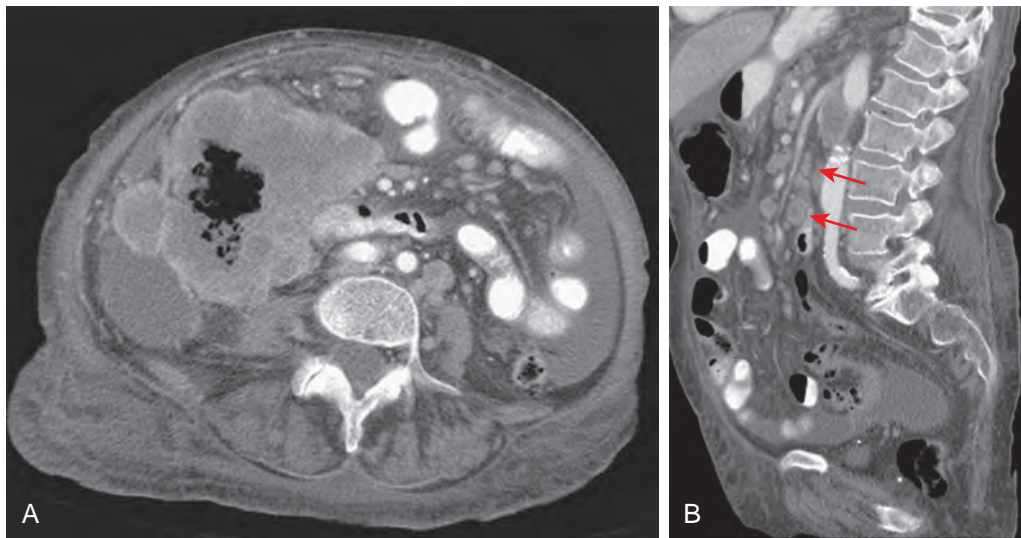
Lymphatic metastases: CT findings. A. Large necrotic carcinoma of the ascending colon with malignant ascites and retroperitoneal adenopathy. B. Sagittal reformatted image shows metastatic lymphadenopathy (arrows) within the small bowel mesentery.
